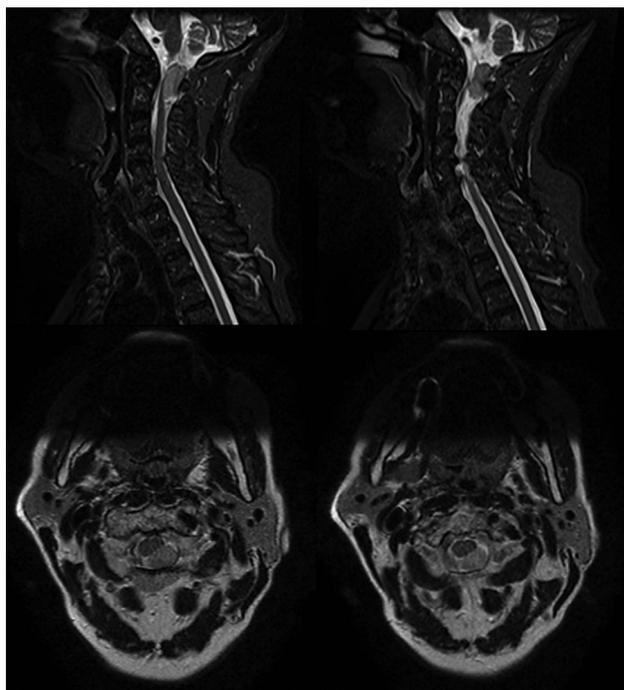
Magnetic resonance imaging scan of the cervical spine showing a solid intradural extramedullary nodule located posteriorly to the vertebral canal at the level of C1 and C2 measuring $28 \times 17 \times 15$ mm, compressing the posterior surface of the medullary cord. It presents isosignal on T1 and hypersignal on T2 with the musculature and moderate/slightly heterogeneous post-gadolinium uptake.
